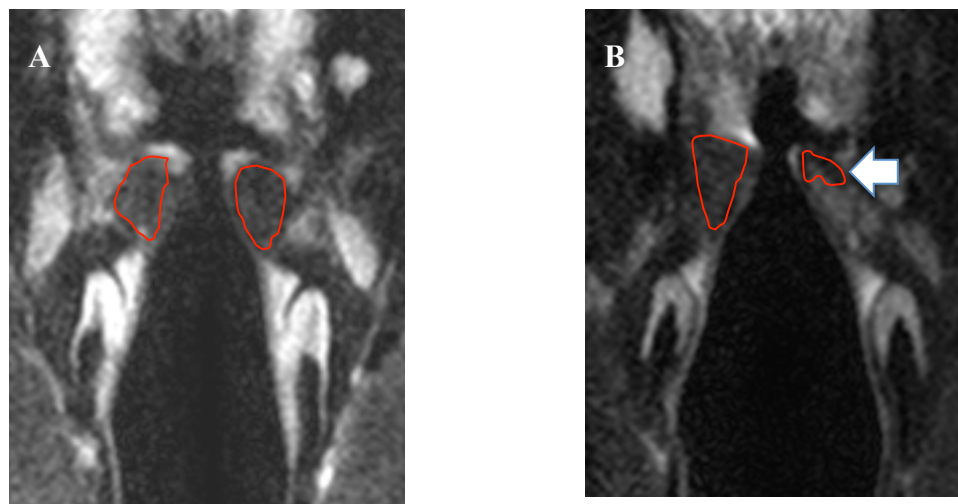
This figure shows T2-MRI of larynx images in coronal view showing the main cross-sectional bulk of thyroarytenoid muscles of a: A) healthy volunteer; and B) unilateral vocal fold paralysis patient. The arrow shows left side paralysis in which the bulk is smaller than the normal side.
